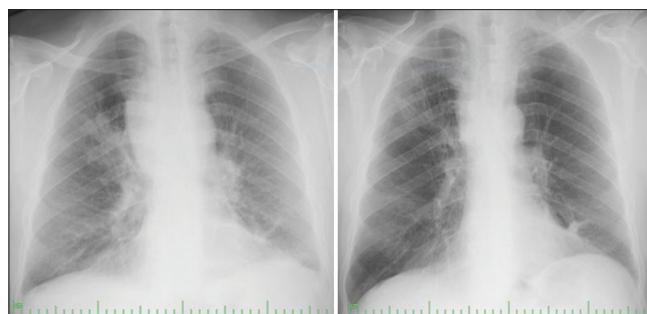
Regression of the lesion was observed on chest X-ray after chemotherapy
